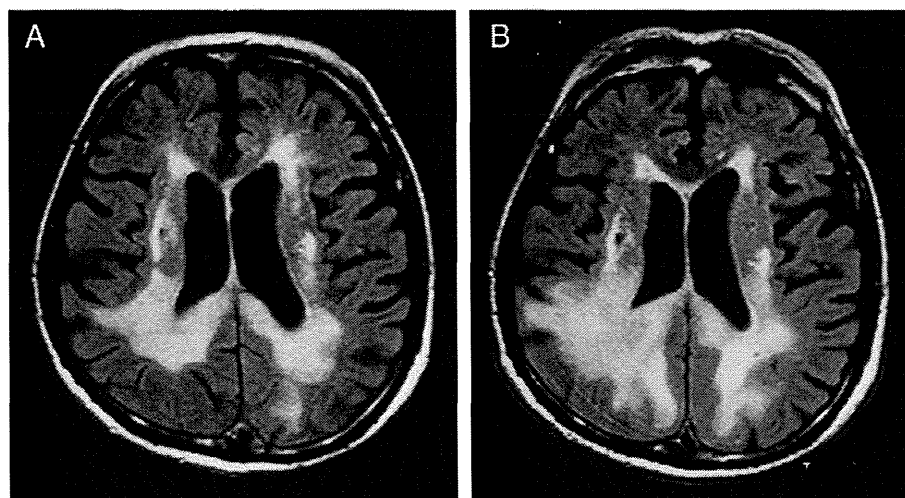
A. FLAIR sequence of brain MRI 15 days after initiation of mefloquine demonstrated abnormal high intensity areas in the bilateral temporal and occipital white matter. B. FLAIR sequence of brain MRI 31 days after the initiation of mefloquine showed lesion expansion.
